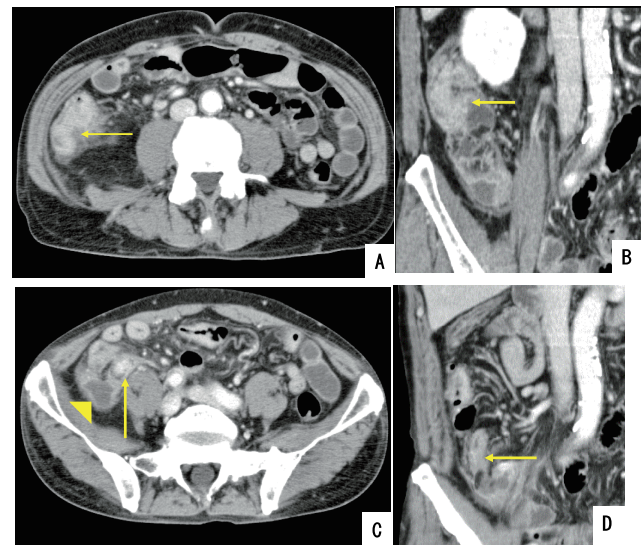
Preoperative contrast-CT findings.
